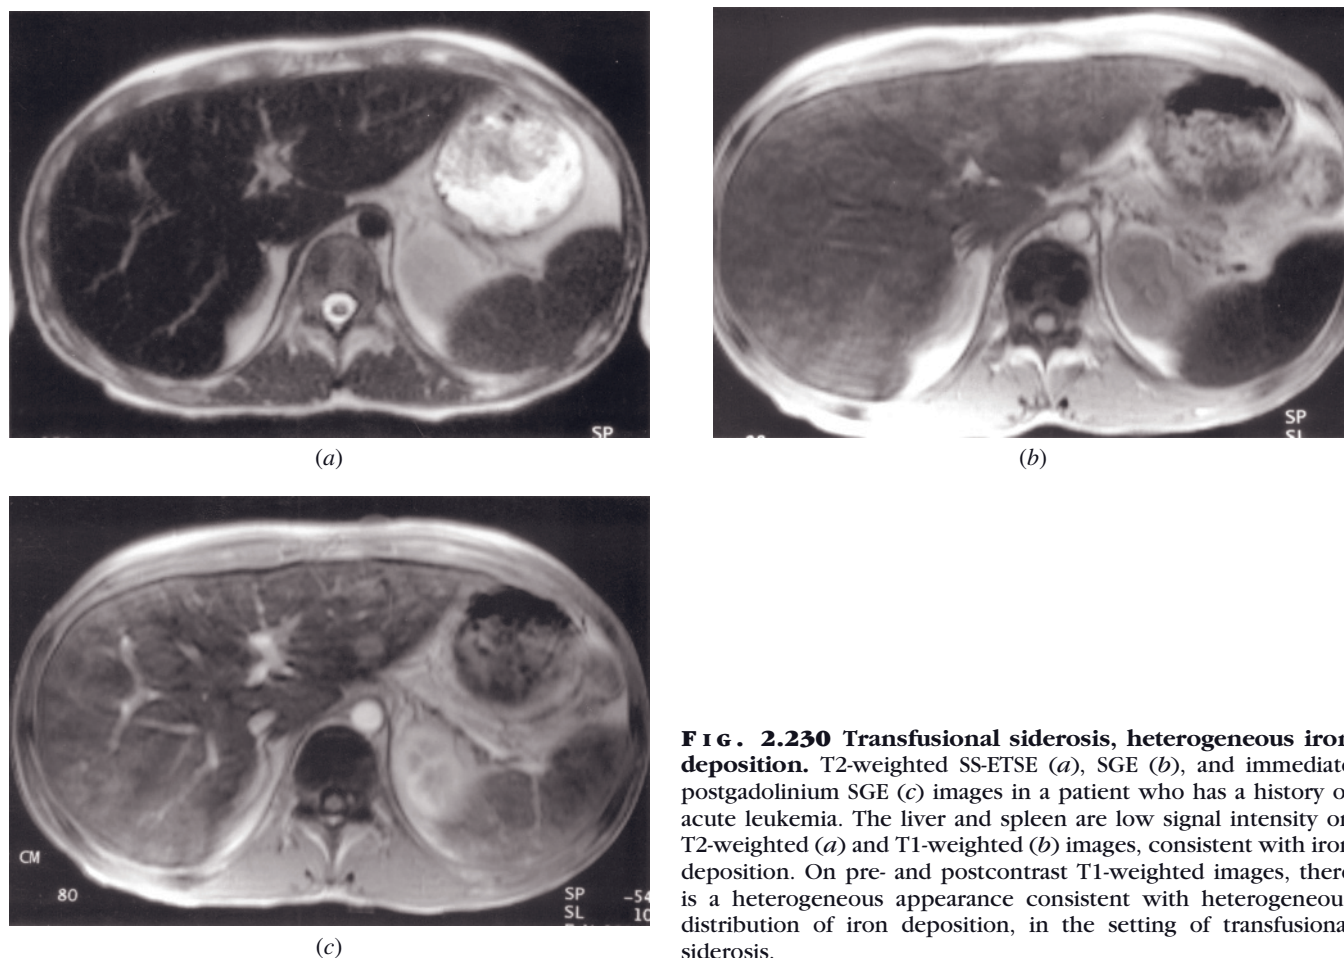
Transfusional siderosis, heterogeneous iron deposition. T2-weighted SS-ETSE (a), SGE (b), and immediate postgadolinium SGE (c) images in a patient who has a history of acute leukemia. The liver and spleen are low signal intensity on T2-weighted (a) and T1-weighted (b) images, consistent with iron deposition. On pre- and postcontrast T1-weighted images, there is a heterogeneous appearance consistent with heterogeneous distribution of iron deposition, in the setting of transfusional siderosis.
